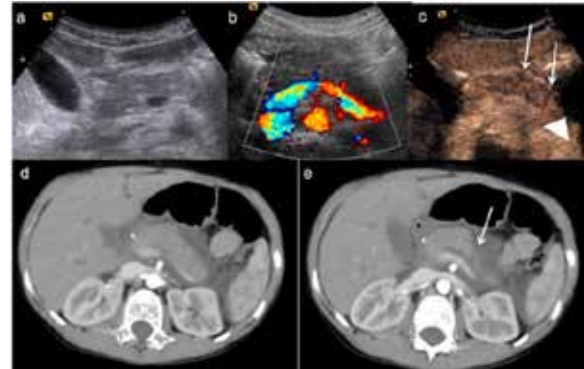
Pancreatic trauma in a child. Images “a”, “b” and “c” are from ultrasound, images “d” and “e” are from computed tomography<sup>11</sup>.
